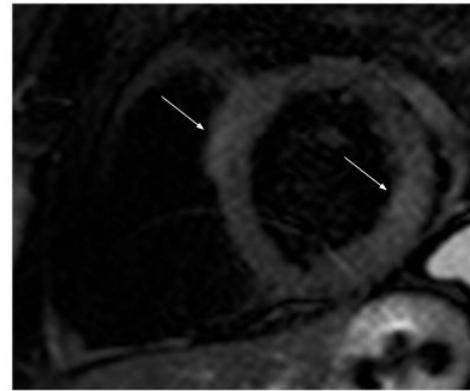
Anteroseptal and lateral (arrows) transmural nodular increased signal intensity in T2-weighted sequence on an MRI 1.5 Tesla scan (Intera, Philips Medical Systems, Best, The Netherlands).
